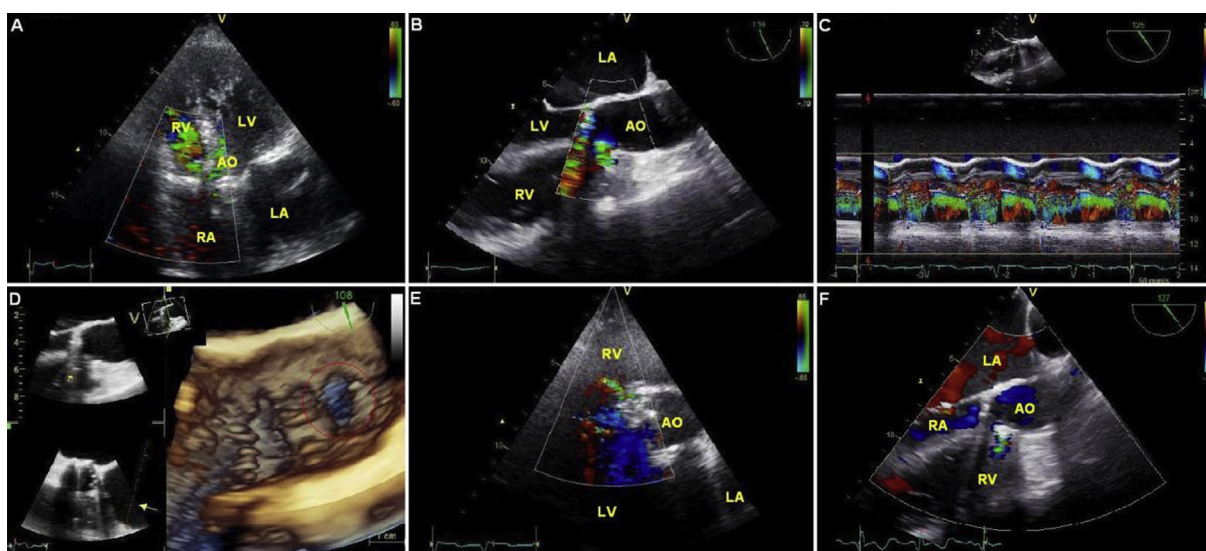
A. Transthoracic echocardiography, B. Transesophageal echocardiography confirming the communication from the aorta to the right ventricle at the level of the right coronary cusp. C. Continuous flow of the communication between the aorta and the right ventricle, D. Three dimensional transesophageal echocardiographic visualization of the aorto-right ventricular fistula, E. Post-procedural transthoracic echocardiography, F. Post-procedural transesophageal echocardiography showing minor residual flow between the aorta and the right ventricular fistula. (AO: Aortic root; LA: Left Atrium; LV: Left Ventricle; RA: Right Atrium; RV: Right Ventricle).
